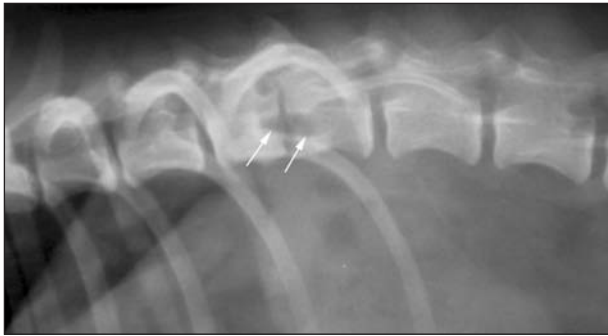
Same lateral radiographic view as in Figure 1. Focal end-plate lysis (arrows) affecting contiguous end plates, indicative of diskospondylitis, is evident.
